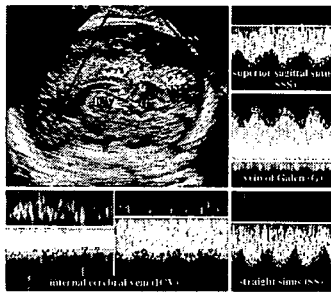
Intra-cranial venous circulation in the median section of fetal brain by transvaginal color Doppler image and physiologic venous-flow velocity waveform patterns of four different veins.
